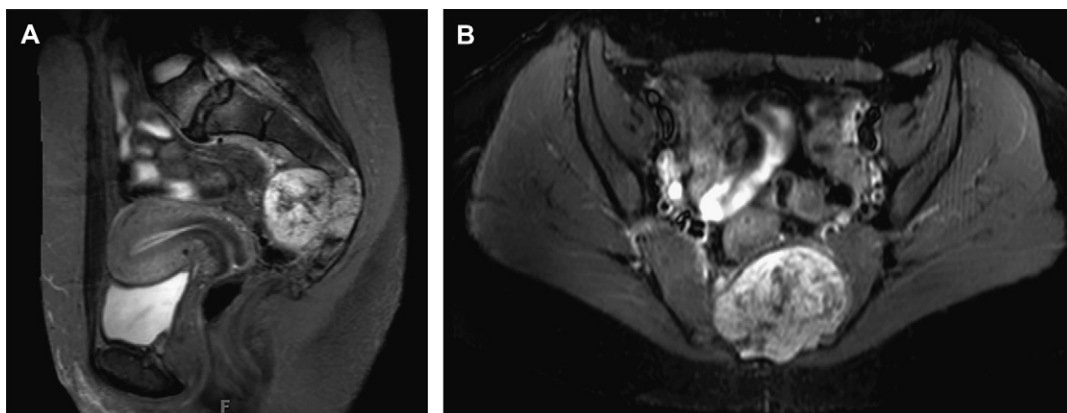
T2-weighted MRI of a distal sacral chordoma shows a hyperintense expansile mass in the sagittal (A) and axial (B) planes.
